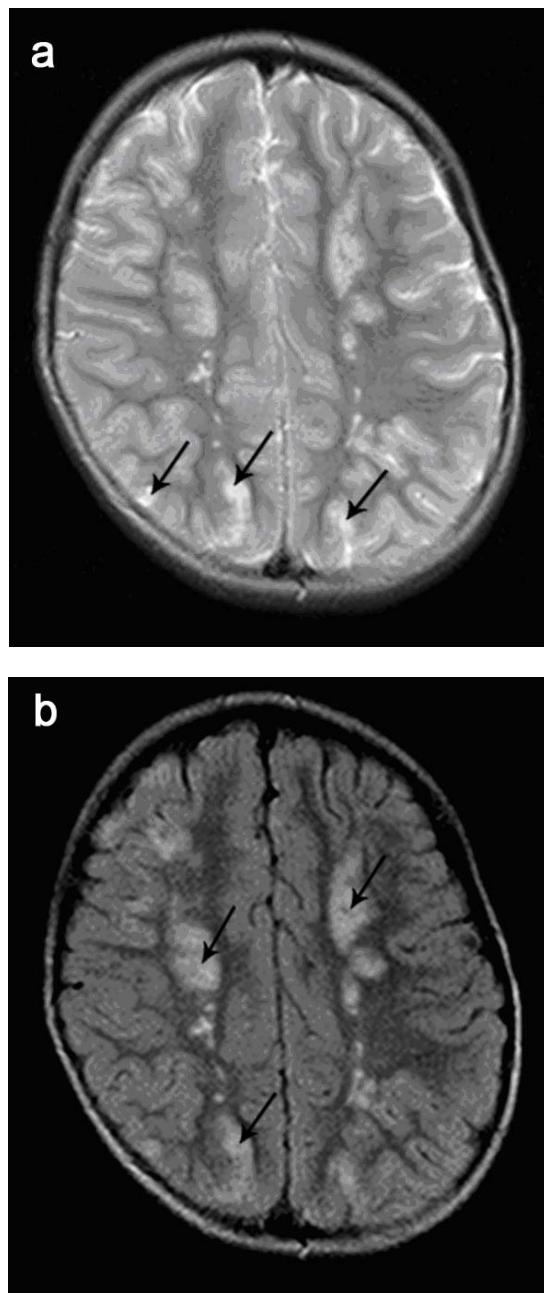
Diffuse, confluent hyper-intense brain lesions were found in both gray and white matter. a - MRI T2 weighted sequences; b - FLAIR weighted sequences.
